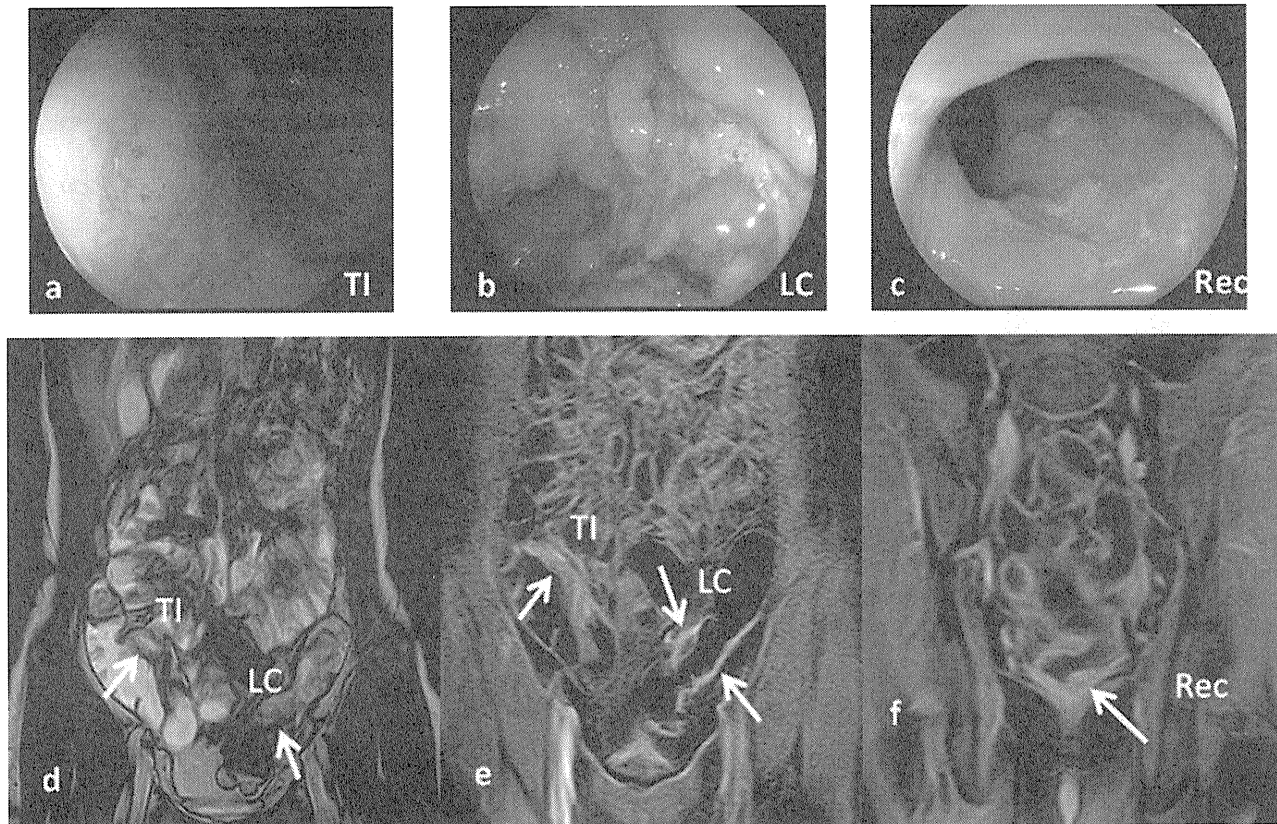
An example of comparison between endoscopy and MREC in terminal ileum and colonic lesions. Conventional colonoscopy detected DMLs in the terminal ileum (a), sigmoid colon (b), and rectum (c). MREC with True SSFP sequence in coronal view (d) and 3D T1-weighted contrast-enhanced GRE sequence (e,f; coronal view) in a patient with multifocal CD. TI: terminal ileum, LC: left sided colon, Rec: rectum.
